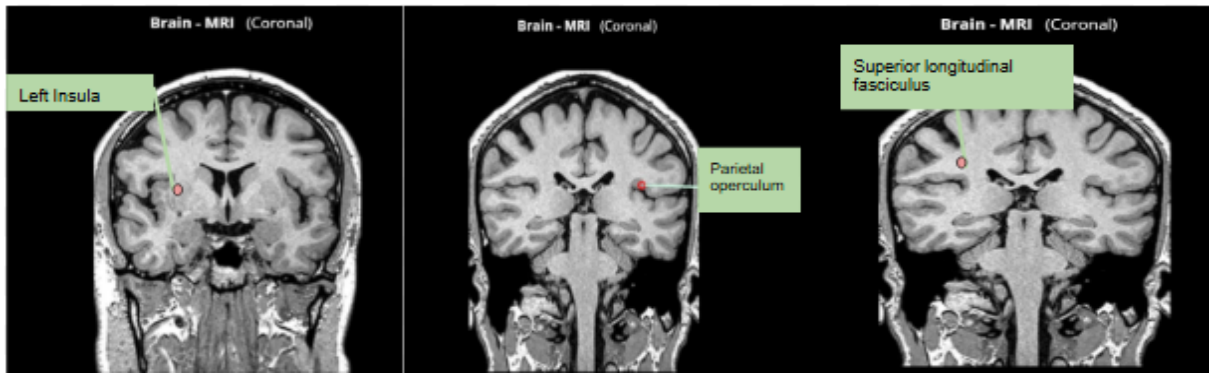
Regions of the brain resulting in increased white matter density in congenital anosmia. Courtesy of IMAIOS © “Antoine MICHEAU, MD , Denis HOA, MD Authors' affiliations, Publication date: Aug 25, 2008, Anatomy of the brain (MRI) - cross-sectional atlas of human anatomy, <https://doi.org/10.37019/e-anatomy/163>
